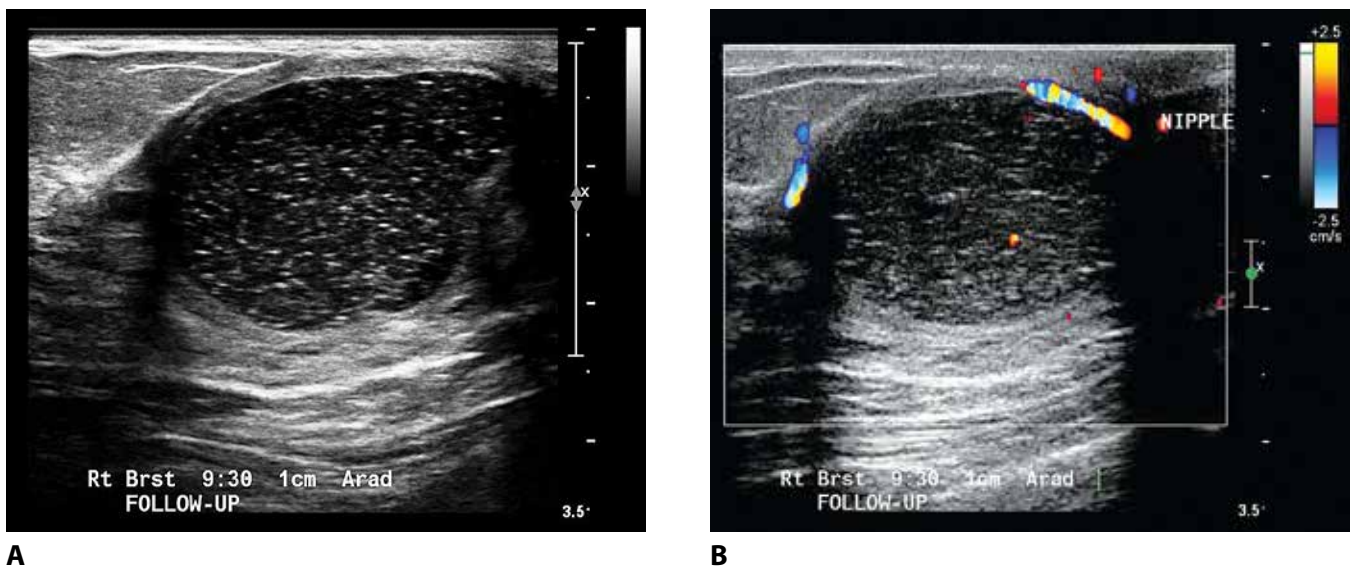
COMPLICATED CYST. A 56-year-old woman with palpable mass just lateral to the nipple. This COMPLICATED CYST fulfills all of the sonographic criteria that define a simple cyst except that it contains low-level echoes throughout (a). Note the visible rim vascularity (b).
